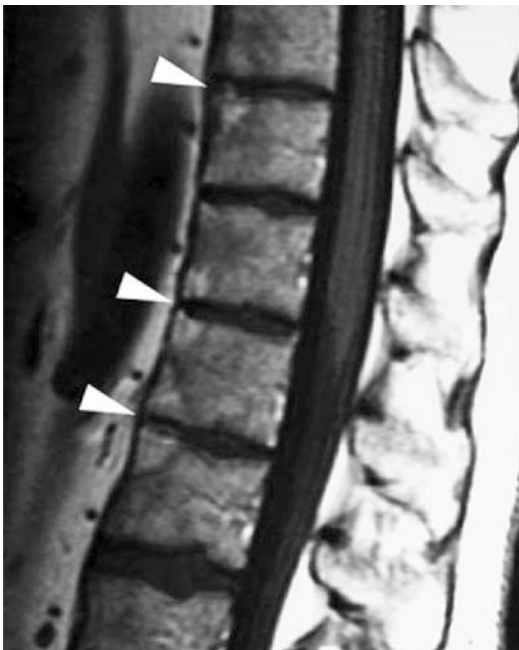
Romanus spondylitis. Sagittal T1-weighted spin echo MR image shows fatty changes within bone marrow of the anterior vertebral body corners at several levels (*arrowheads*)
